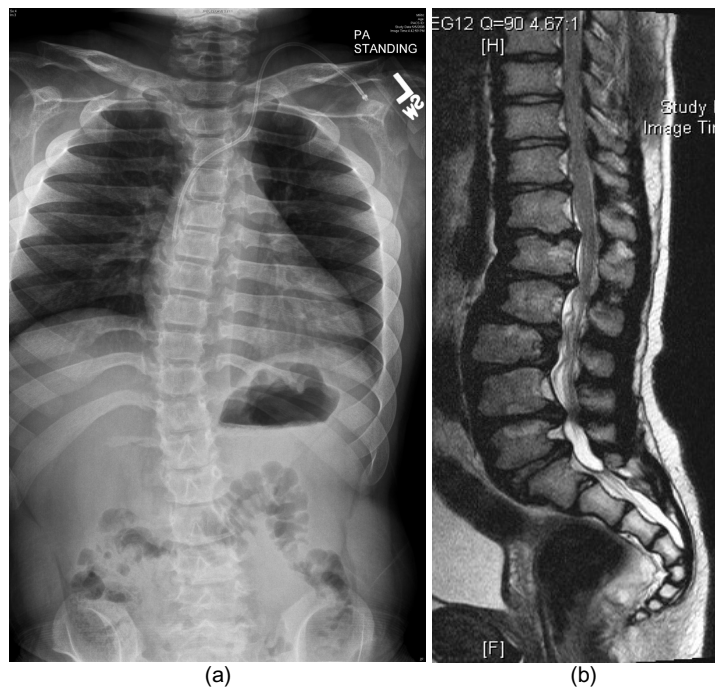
Images from patient #3: a) 33° scoliosis with coarseness of the bones and widening of the ribs, b) magnetic resonance imaging demonstrates mild thoracolumbar kyphosis and typical anterior vertebral body deficiency seen in MPS.
